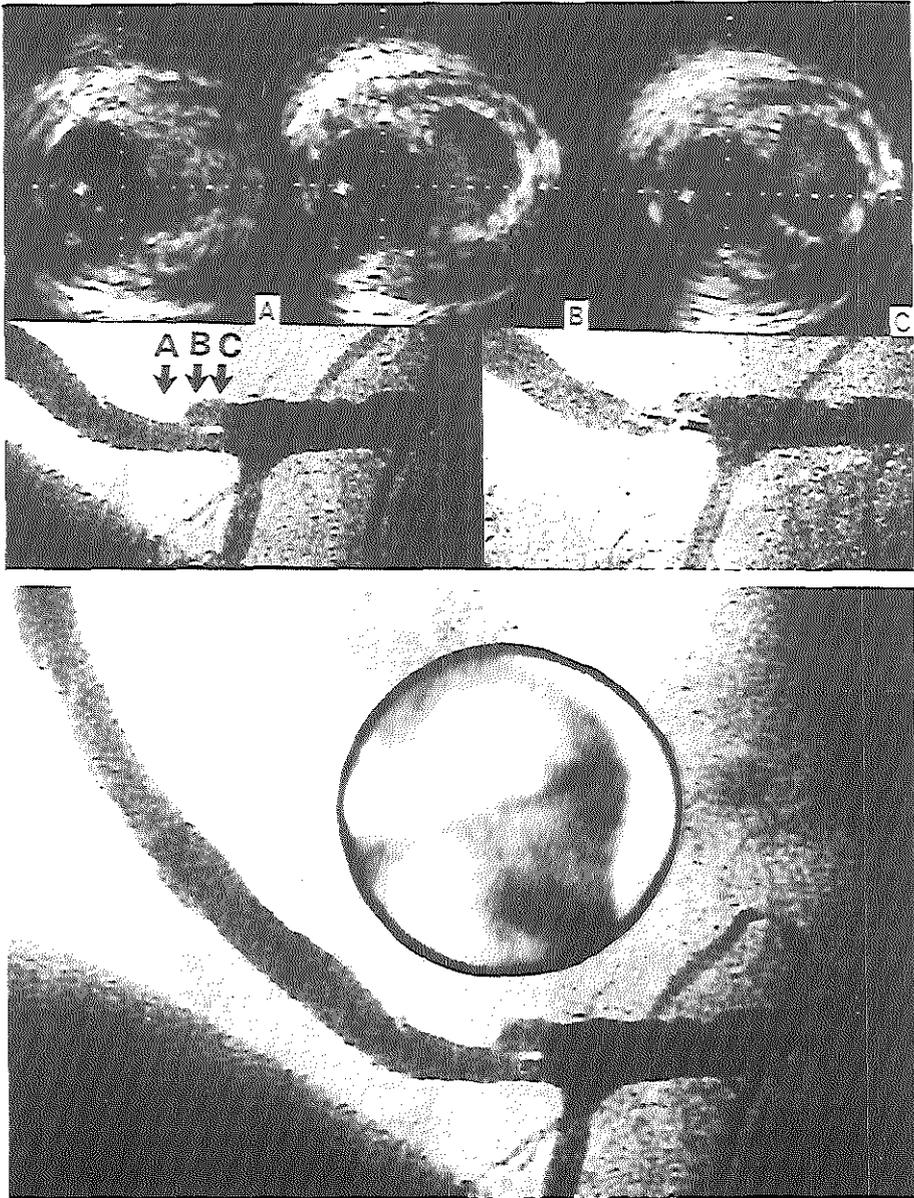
Digital angiograms showing a complex plaque in the mid-segment of a saphenous vein graft 7 years after implantation. Three ultrasonic cross-sections obtained from proximal to distal at the site of the lesion (top panel, A, B and C) show the presence of a soft eccentric plaque containing a cavity communicating retrogradely with the vessel lumen. The corresponding angioscopic image (lower panel) shows a friable lesion composed of red-greyish material and suggestive of organizing thrombi.
